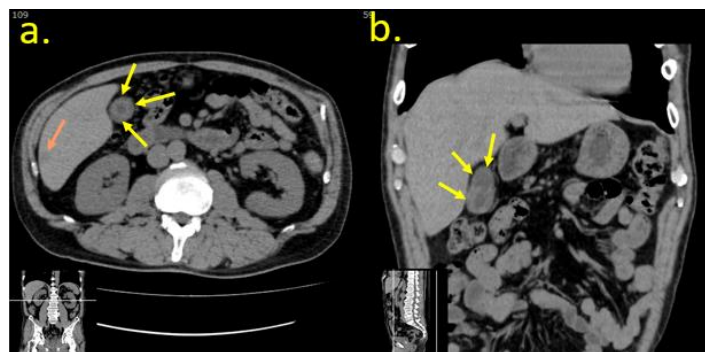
Plain abdominal CT scan
